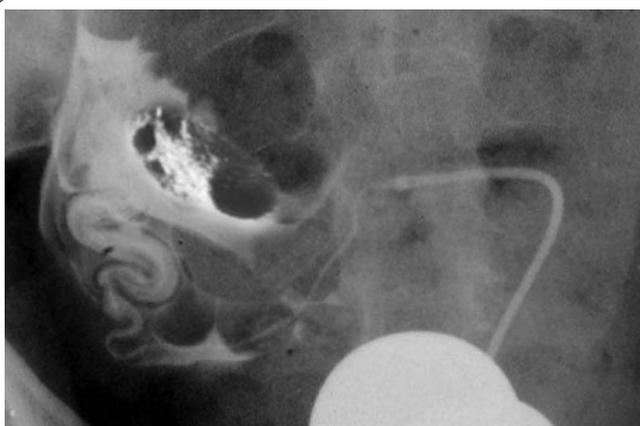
Combined selective salpingography and ovarian sonography showing the ovulation site away from the picking fimbrial end of the tube indicating failed ovum picking. Notice the shape of the fimbrial end which is seen as radio-opaque area following the ampullary part of the tube.
